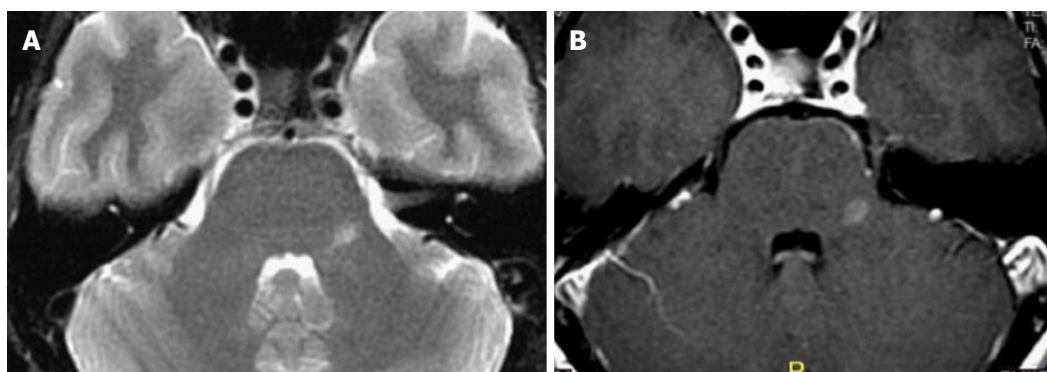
Multiple sclerosis. A 40-year-old female with 2 mo history of left facial pain/numbness and difficulty talking (scanning speech). Axial T2 (A) and axial post-contrast MR (B) images show isolated lesion in the left MCP. Due to suspicion for demyelinating disease MRI of the spine and CSF analysis was recommended. Additional lesion found in the thoracic cord (not shown) and CSF led to the diagnosis of MS. MCP: Middle cerebellar peduncles; CSF: Cerebrospinal fluid; MRI: Magnetic resonance imaging; MS: Multiple sclerosis.
